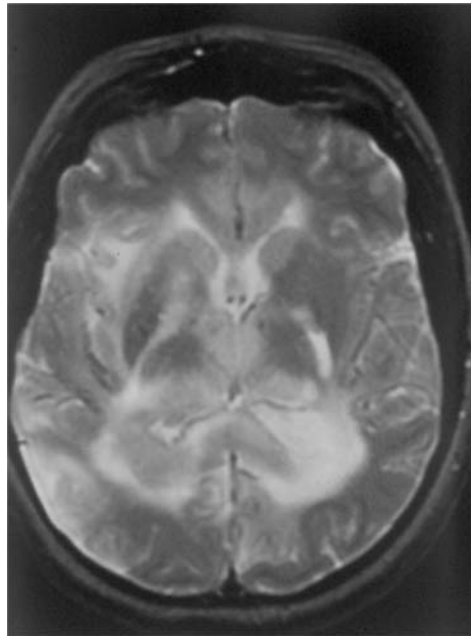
Gliomatosis cerebri, MRI, T2-weighted image. From the Neuroradiological Unit, Dpt Neuroscience, University of Turin
